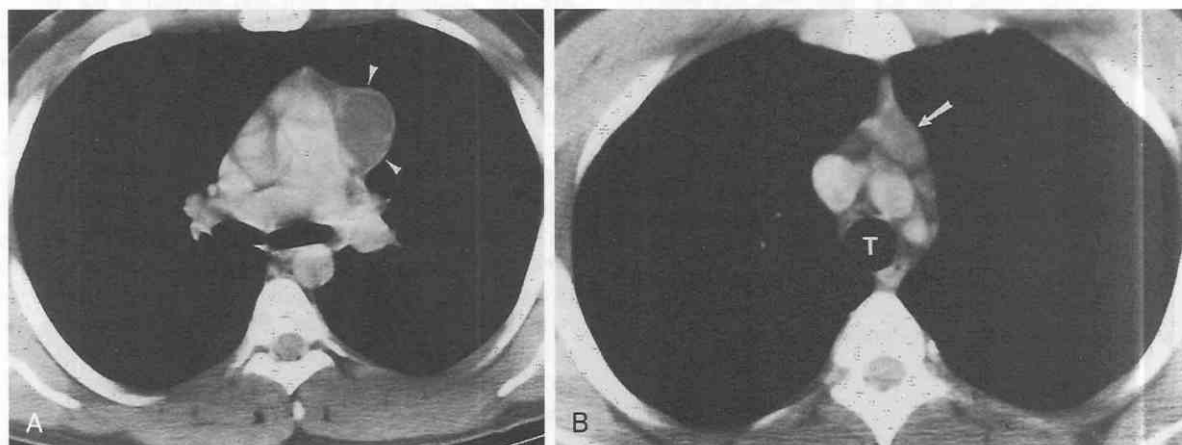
Seminoma associated with a thymic cyst. A, Contrast-enhanced CT shows well-circumscribed water-attenuation mass in anterior mediastinum. The wall (arrowheads) is thin but perceptible. B, A more cephalic image reveals a soft tissue component of the mass (arrow). Resection revealed the seminoma. T, trachea.
